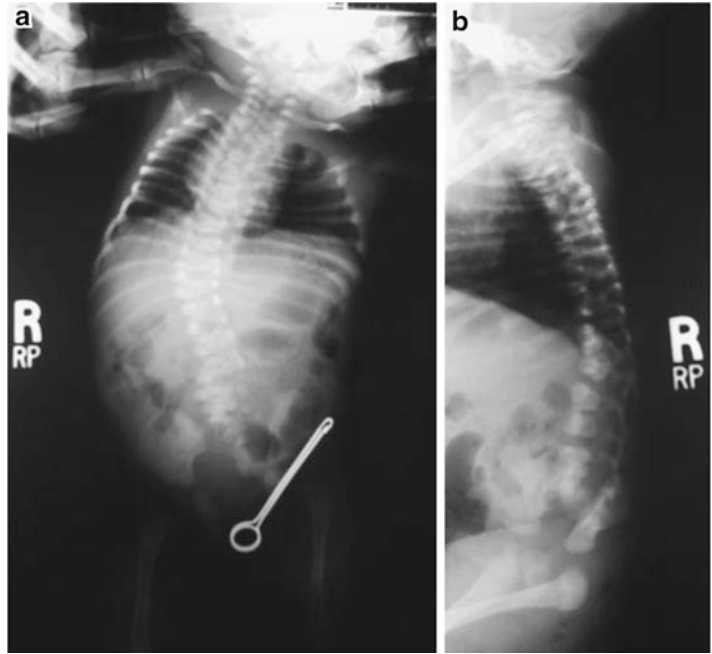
Radiographs of another infant with spondylothoracic dysostosis showing severe chest deformity
